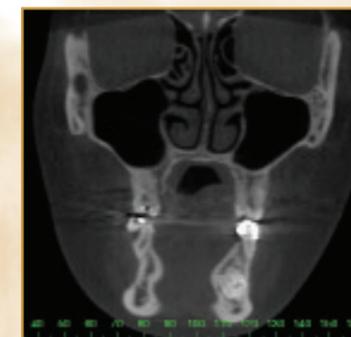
CBCT coronal section of Case 2 patient showing buccolingual expansion and thinning on the left side.
